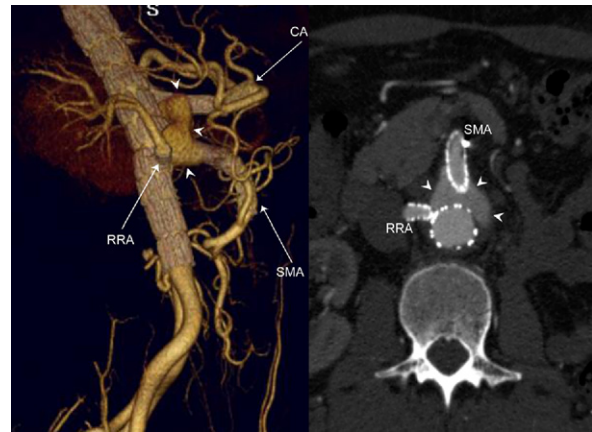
Sagittal oblique volume-rendered and axial source CTA images 1 month post-f-EVAR. Sagittal oblique volume-rendered CTA from a right-sided projection demonstrates a large endoleak (white arrowheads) involving the visceral segment of the abdominal aortic stent graft: celiac artery (CA), superior mesenteric artery (SMA), and right renal artery (RRA). Exact site of endoleak could not be identified. Axial source CTA image provides the same information. CTA, Computed tomographic angiography; f-EVAR, fenestrated endovascular aortic aneurysm repair.
